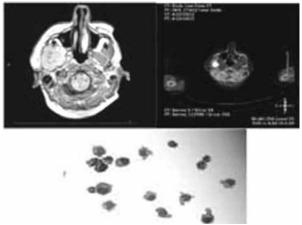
MRI, PET imaging and CSF
